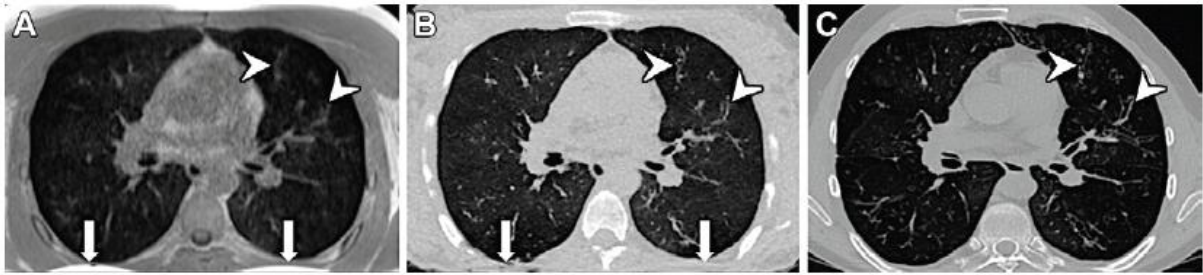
Example images of the lung in a 20-year-old female with Cystic Fibrosis from the external validation dataset. On (A) Lung MRI with ultrashort echo-times (UTE-MRI), aliasing of the mammary glands (white arrows) is visible partially outside the field-of-view due to the Cartesian k-space sampling in the anteroposterior axis of UTE-MRI. The aliasing artifacts were visible in the posterior extrapulmonary subcutaneous fat and did not impair the lung area on (A) UTE-MRI and were still noticeable on (B) synthetic CT images generated by AI from UTE-MRI. Note the presence of mild bronchiectasis in the left upper lobe (white arrowheads), with a conspicuous delineation on (B) synthetic CT and (C) corresponding real CT.
